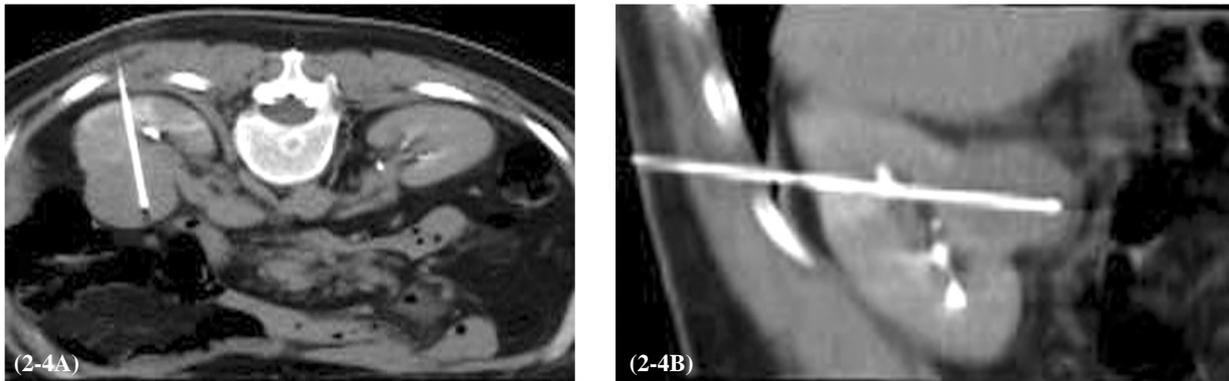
2nd RFA session: Patient in a prone position and axial, sagittal CT images obtained at delayed phase shows RF needle electrode within the tumor.
